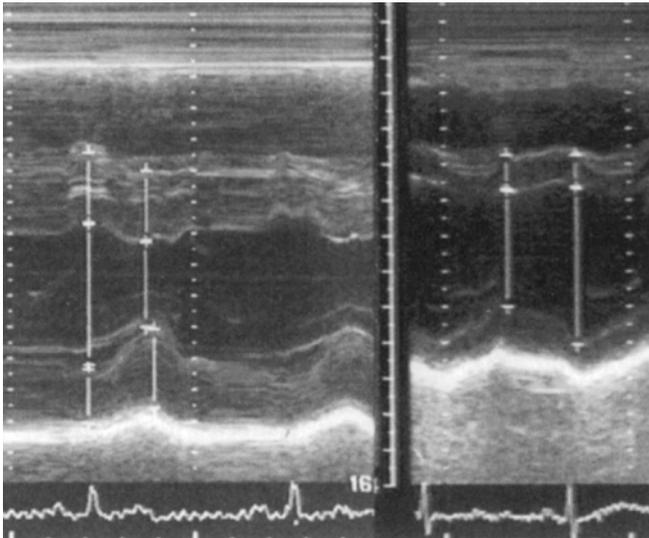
Two-dimensional and M mode echocardiograms showing severe left ventricular hypertrophy with marked thickening of the intraventricular septum and posterior wall (left) and normal echocardiogram (right).
